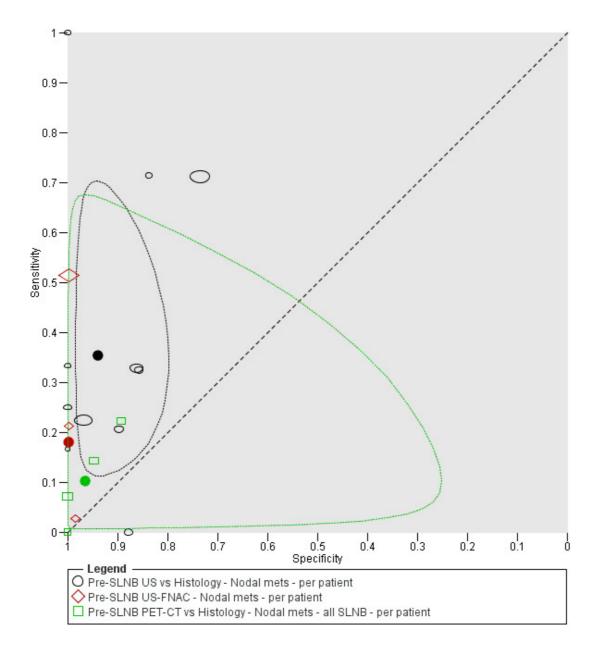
Summary ROC plot comparing pre-SLNB ultrasound vs ultrasound plus FNAC vs PET-CT.
